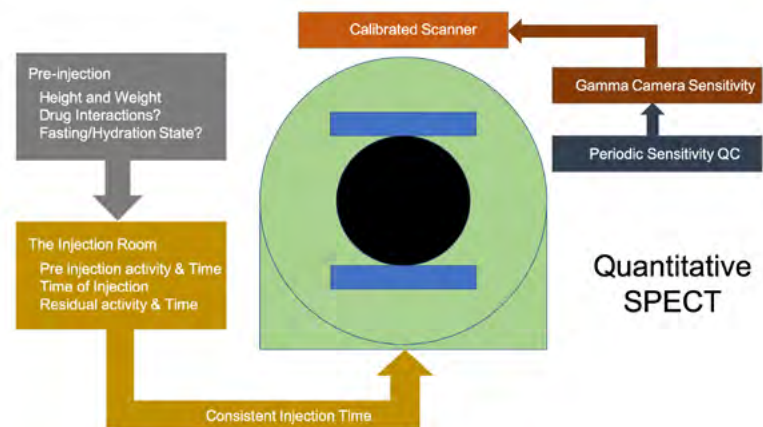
Operational steps required to perform quantitative SPECT.
